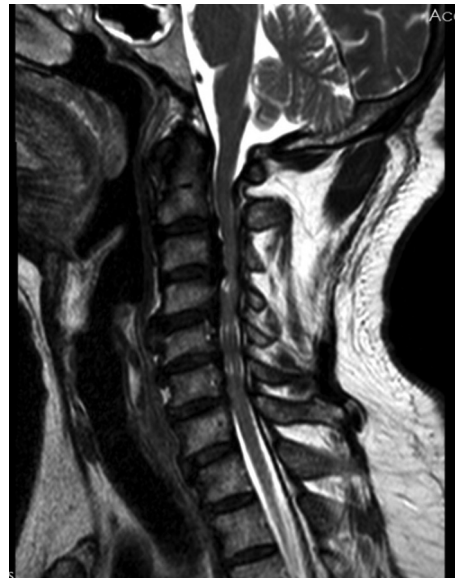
Preoperative magnetic resonance imaging (T2 sagittal) showing severe cervical canal stenosis with myelopathy at the C3–C6 level.
